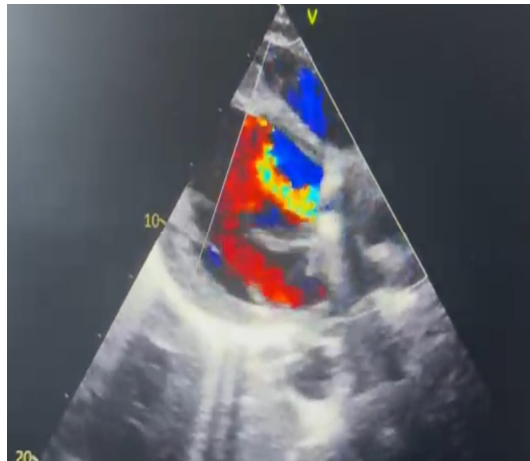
apical 4-chamber echocardiographic
